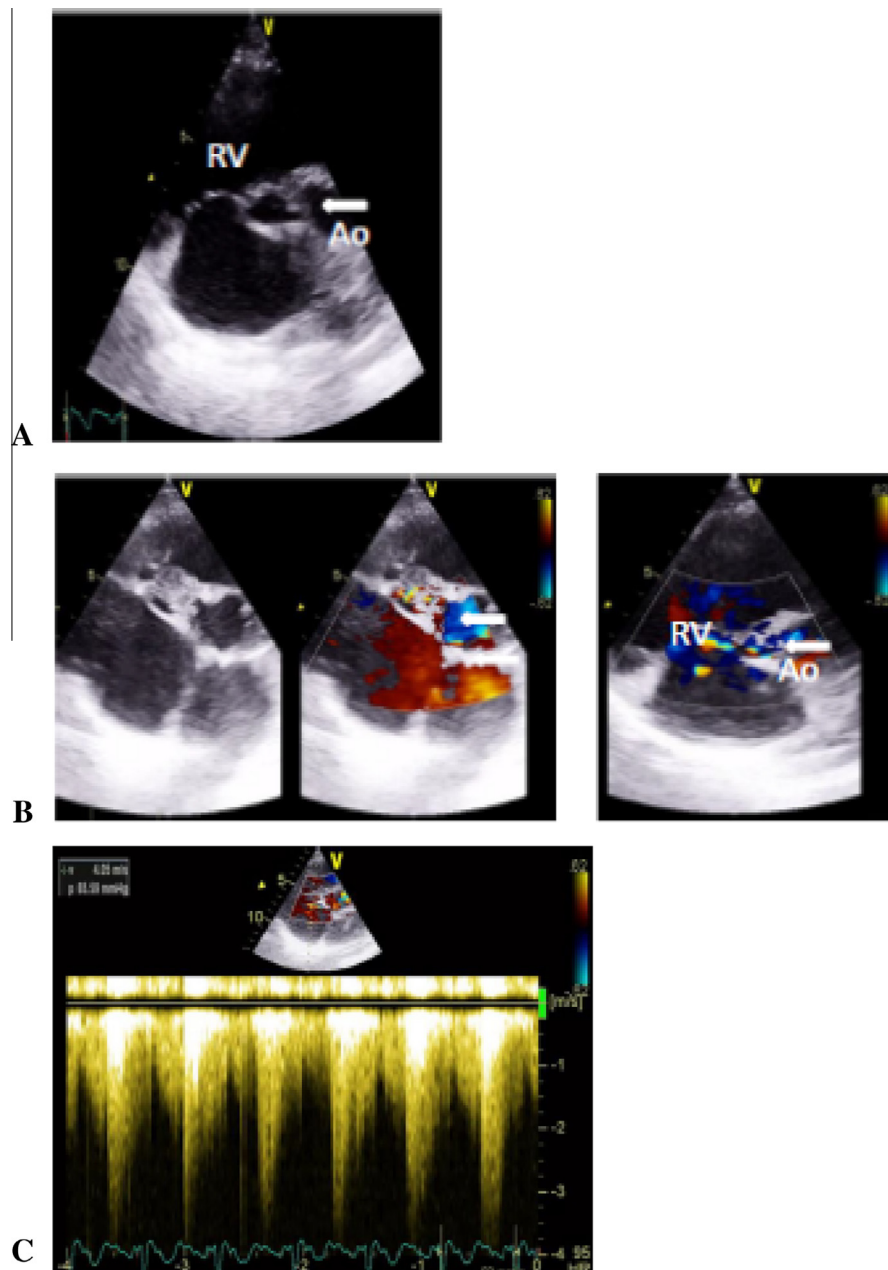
Two-dimensional transthoracic echocardiography showing rupture of the right sinus of Valsalva aneurysm and flow of blood into the right ventricle. (A) Shows the right sinus of Valsalva aneurysm (arrow). (B) Color Doppler interrogation shows the flow between the ruptured right sinus of Valsalva aneurysm and the right ventricle (arrow). (C) Doppler interrogation shows the presence of a ruptured right coronary sinus of Valsalva aneurysm with high-velocity flow (4 m/s) into the right ventricular cavity during both systole and diastole. Ao = aorta; RV = right ventricle.
